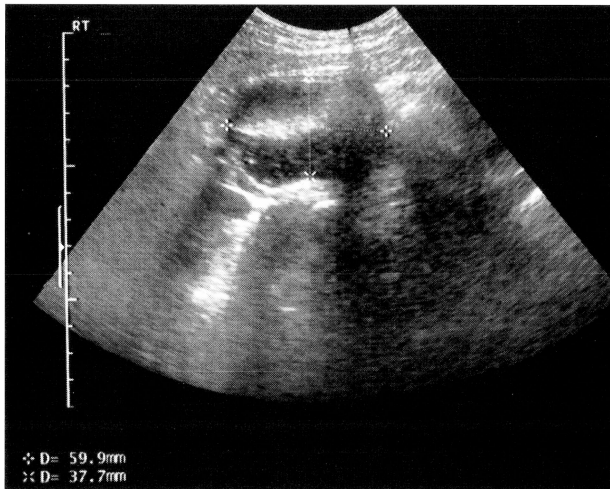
Transabdominal ultrasonography of a part of the right ovary shows a cystic mass (6 x 3.8 cm) with echogenic elements.
